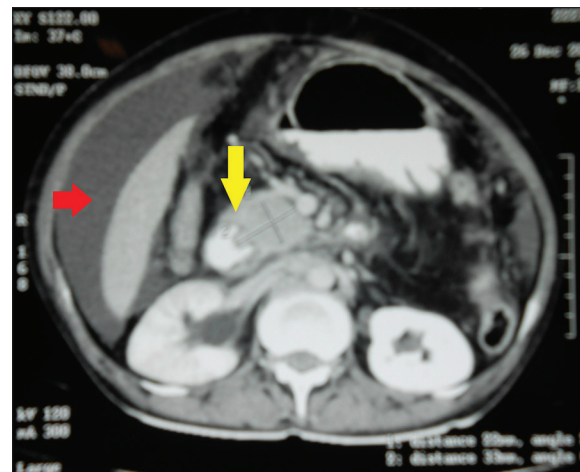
Contrast enhanced computed tomography of abdomen of the patient showing a periampullary mass (yellow arrow) with ascites (red arrow) and dilated intrahepatic biliary radicles
